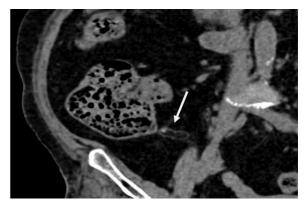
Non-contrast Enhanced Computed Tomography coronal plane
